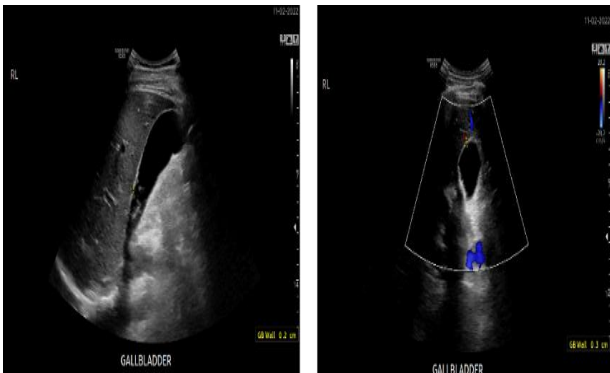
Gallbladder ultrasound findings sludge and multiple mobile gallstones in the gallbladder lumen, mild gallbladder distention, positive sonographic Murphy's sign, but no gallbladder wall thickening, no pericholecystic fluid, and no biliary dilatation.
